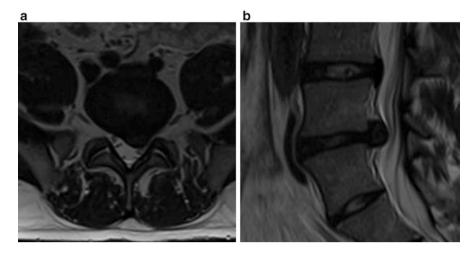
Axial (a) and sagittal (b) T2-weighted MR images of L5-S1 left paracentral extrusion severely narrowing the lateral recess and displacing the S1 nerve root
